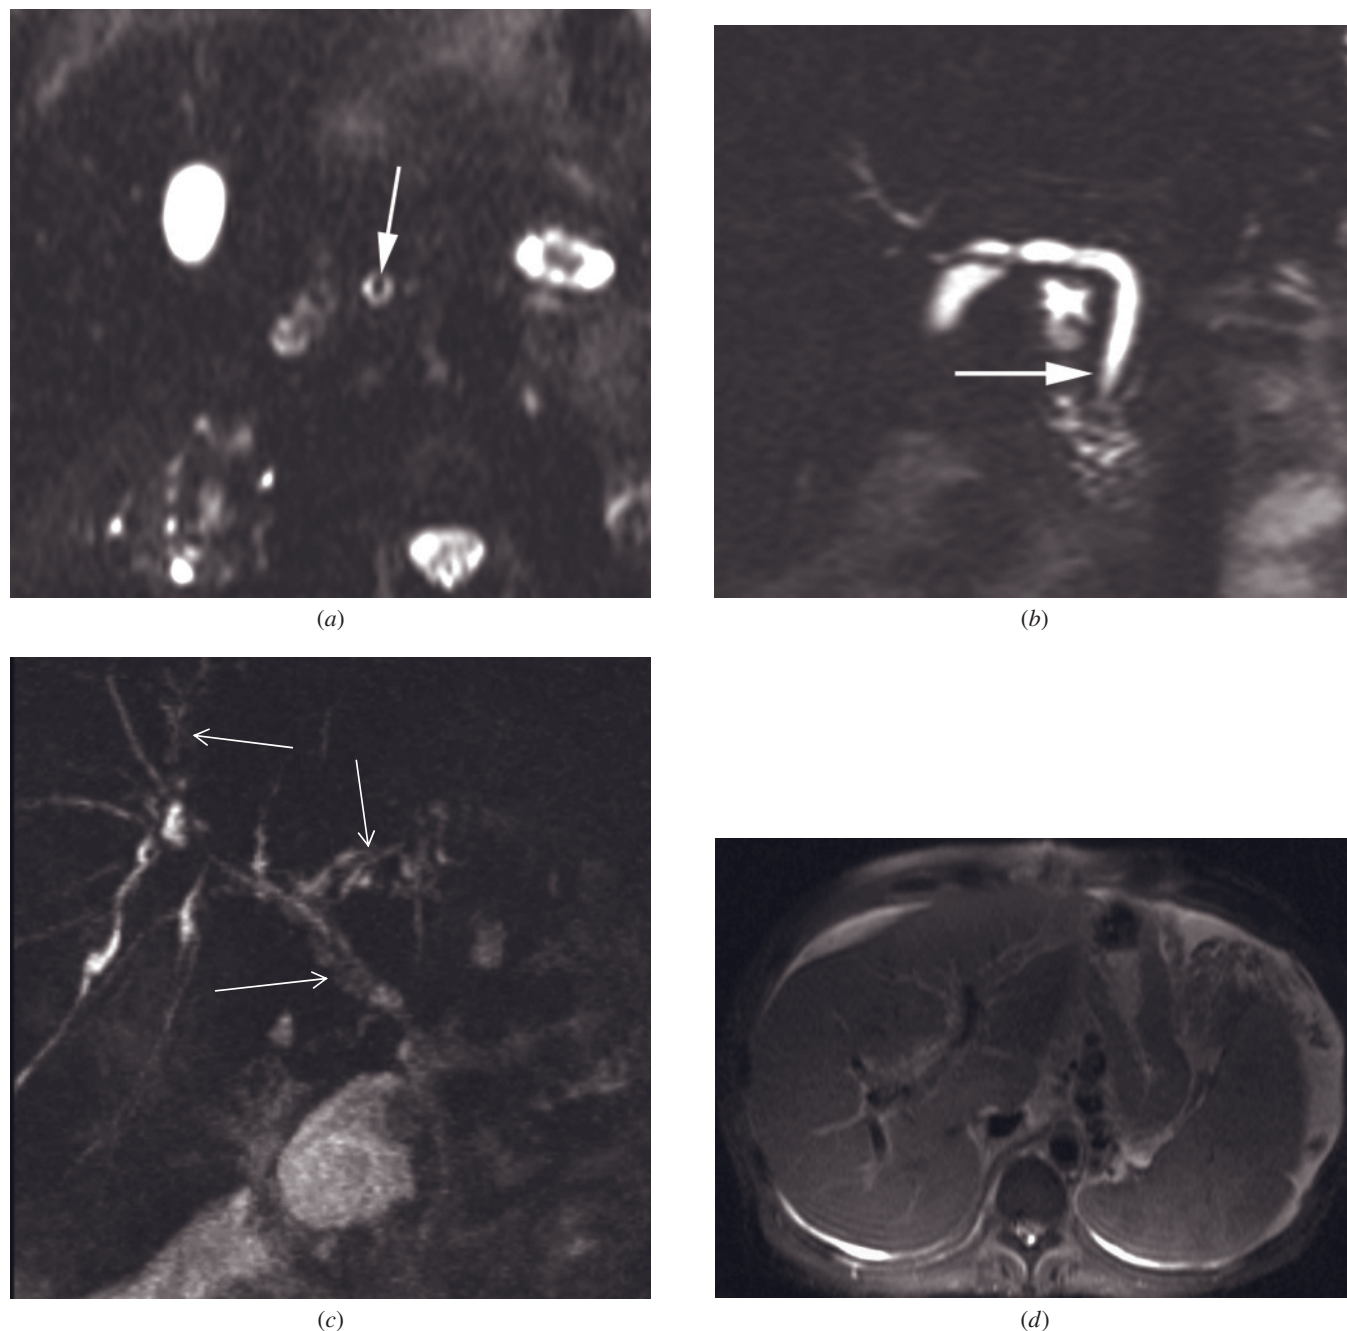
Flow artifact mimicking a stone in an asymptomatic person. The axial thin-slab MRCP image (*a*) shows a small, signal-void round area (arrow, *a*) in the center of the preampullary common bile duct (CBD). The paracoronaral thin-slab MRCP image (*b*) demonstrates a normal, fluid-filled CBD (arrow, *b*), excluding the presence of a stone. Low signal of debris filled ducts masks dilated bile ducts. Coronal thick-section fast spin-echo (*c*) and transverse T2-weighted fat-suppressed single-shot echo-train spin-echo (*d*) images demonstrate dilated and debris-filled bile ducts developing secondary to an obstruction in another patient who had prior liver transplantation. Dilated and debris-filled CBD and intrahepatic bile ducts show less signal (arrows, *c*). Note the portal hypertension findings and ascites on T2-weighted image (*d*).
